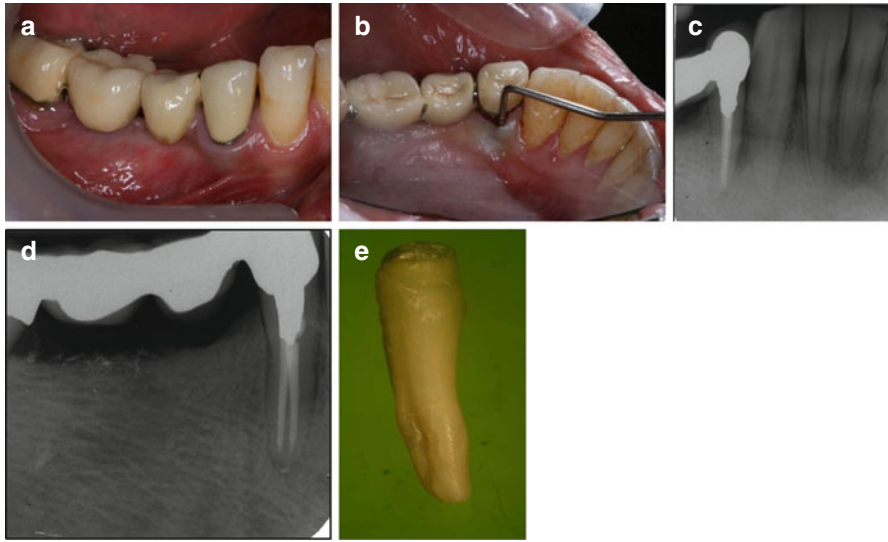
(a–e) The mandibular first premolar was used as a mesial abutment for a four-unit bridge (a). The patient presented for a routine examination with no symptoms. Upon examination, a 7 mm probing defect was found on the lingual gingivae (b). There was no probing on the buccal aspect. The radiographs (c, d) revealed two well-condensed canals with gutta-percha and a wide metal post in the coronal part of the root. A lateral radiolucent area can be seen next to the middle third of the root in the mesial aspect. Since these signs were not present when the endodontic and restorative procedures were performed 6 years earlier, a diagnosis of asymptomatic apical periodontitis was made and the tooth extracted (e). A hairline fracture can be seen on the lingual aspect. As demonstrated in this case, the use of a mandibular or a maxillary sole abutment for a bridge is highly inadvisable due to the large horizontal and torquing forces during function (Courtesy Dr. E. Venezia)
